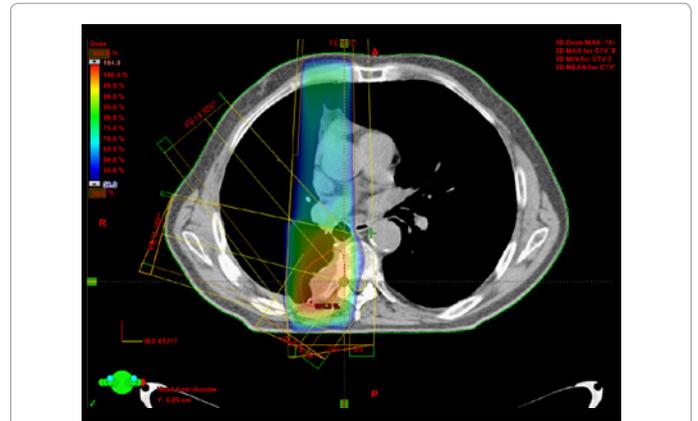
Treatment planning CT scan showing the dose to the reirradiated spinal cord at the level of the 8. thoracic vertebra (total dose to the ICRU reference point 30 Gy, dose per fraction 3 Gy). The maximum dose to the spinal cord equalled 98% of the reference dose. The lowest dose level displayed here is the 50% isodose. The treatment planning system was Eclipse by Varian Inc.
